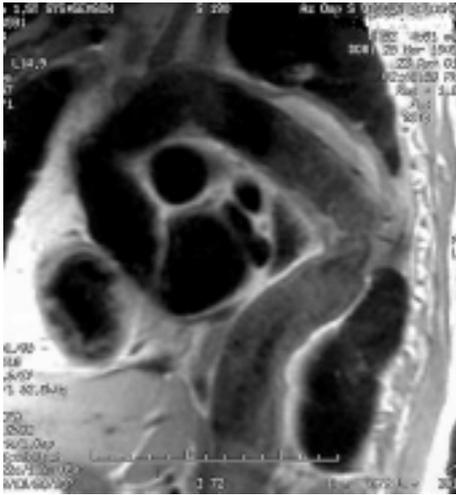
T1-weighted magnetic resonance spin-echo sequence on an oblique sagittal plane performed 1 year after the endovascular procedure and showing a significant reduction in the size of the periprosthetic collection without evidence of any perigraft leak.
